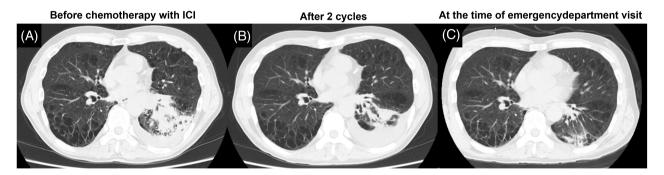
Comparison of computed tomography scan images before chemotherapy with immune checkpoint inhibitors (A) after two treatment cycles (B), and during emergency department visits (C). The size of the primary lesion and volume of the pleural effusion were decreased. No new shadows were observed.
